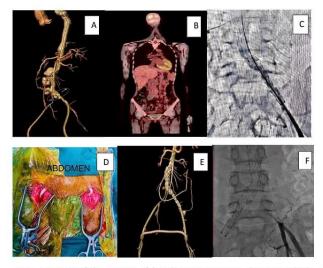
Details of the patient: A) baseline CT angiogram showing multiple pseudoaneurysms in abdominal aorta involving both common iliac artery and significant stenosis in right iliac artery, procedural; B) PET showed no disease activity; C) Cine showing Stent graft deployed from infrarenal aorta to left common iliac artery; D) Femoro-femoral cross over PTFE graft; E) Follow up CT angiogram showed exclusion of pseudoaneurysm, patent PTFE graft with type 2 endo-leak; F) Cine showed no endoleak from right side contrast injection.
